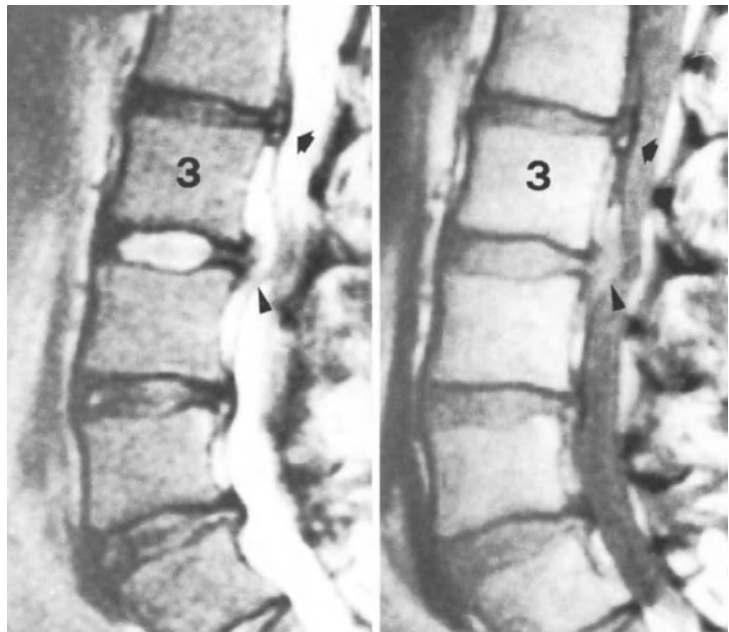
MR images of a patient with disc herniation at multiple levels. Sagittal scans show a large retroligamentous extruded herniation at L3-L4 level (arrowheads), which was responsible for the radicular symptoms. An extruded herniation at L2-L3 level (arrows) and contained herniations at L4-L5 and L5-S1 levels are also visible. The patient underwent discectomy only at L3-L4 level with complete disappearance of radicular symptoms.
